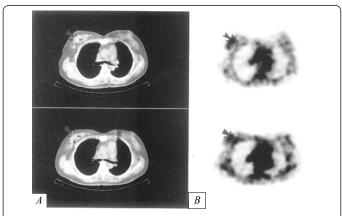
The pre-(above) and post-treatment (below) CT imaging(A) and hybrid ^{99m}Tc-HL91 SPECT imaging (B) in a breast cancer patient with response to neoadjuvant chemotherapy. After neoadjuvant chemotherapy, the radioactivity of ^{90m}Tc-HL91 in breast cancer area was no significant difference, with the tumor to non- tumor HL91 radioactivity ratio was 2.33(pre-treatment) and 2.46(post-treatment) respectively.
